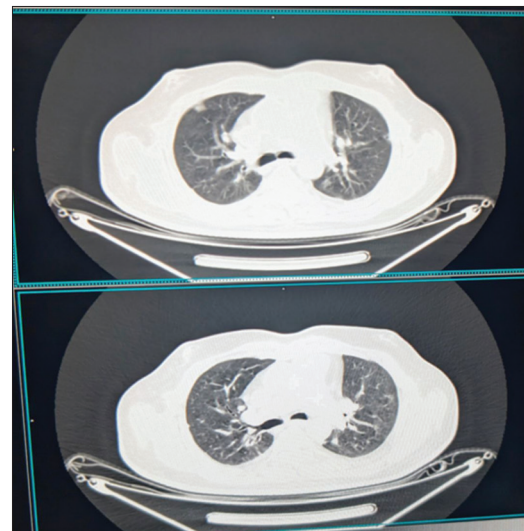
Follow-up computed tomography showing resolution of lesions
